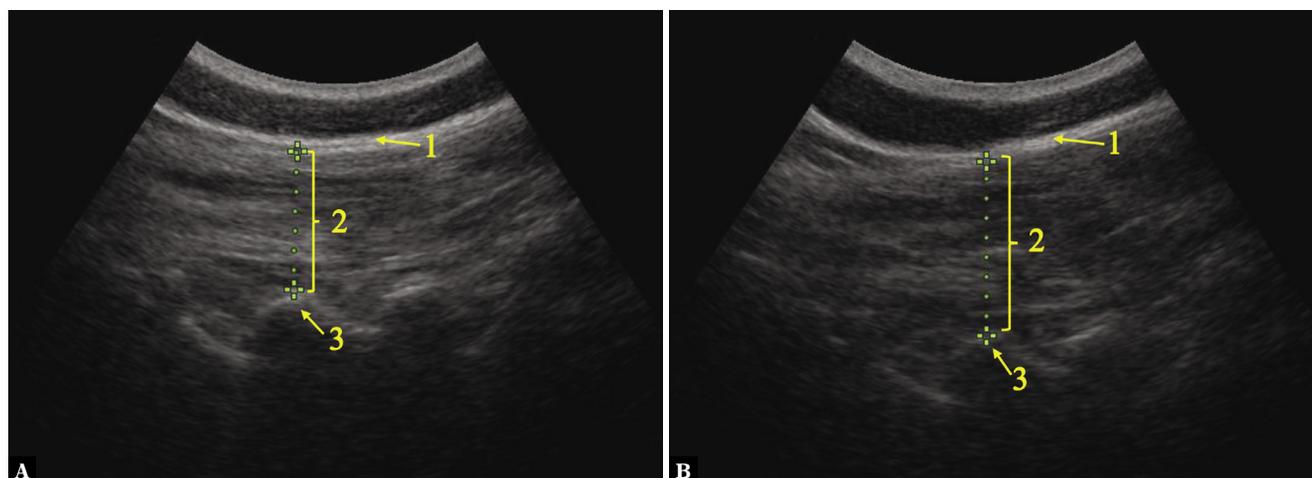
Sonography image of the lumbar multifidus in level of L5/S1 zygapophyseal joints. A. Rest condition. B. Contraction condition. 1 – fascial layer; 2 – lumbar multifidus; 3 – L5/S1 zygapophyseal joint
